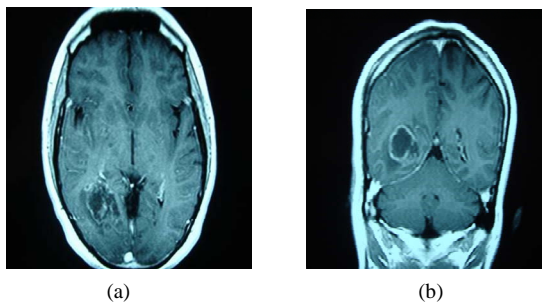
MRI with intravenous contrast. (a) T1-weighted transversal MRI with intravenous contrast. This image reveals a mass (GBM) located inside the occipital lobe with 3 × 6cm of dimension, which is surrounded by edema with compressive effects on the ventricular system; (b) T1-weighted coronal MRI with intravenous contrast. This image reveals heterogeneous and ring enhancement. The central hypodense core represents necrosis, the contrast-enhancing ring is composed of highly dense neoplastic cells with abnormal vessels permeable to contrast agents. The peripheral zone of non enhancing low attenuation is vasogenic edema containing varying numbers of invasive tumor cells.
